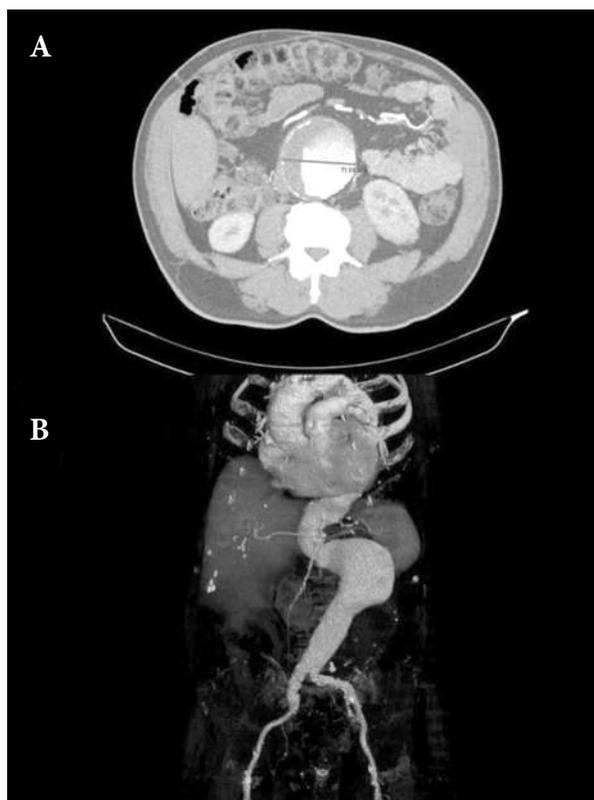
and 1B. A. Abdominal aortic aneurysm, axial CT scan; B. Abdominal aortic aneurysm, virtual reconstruction
